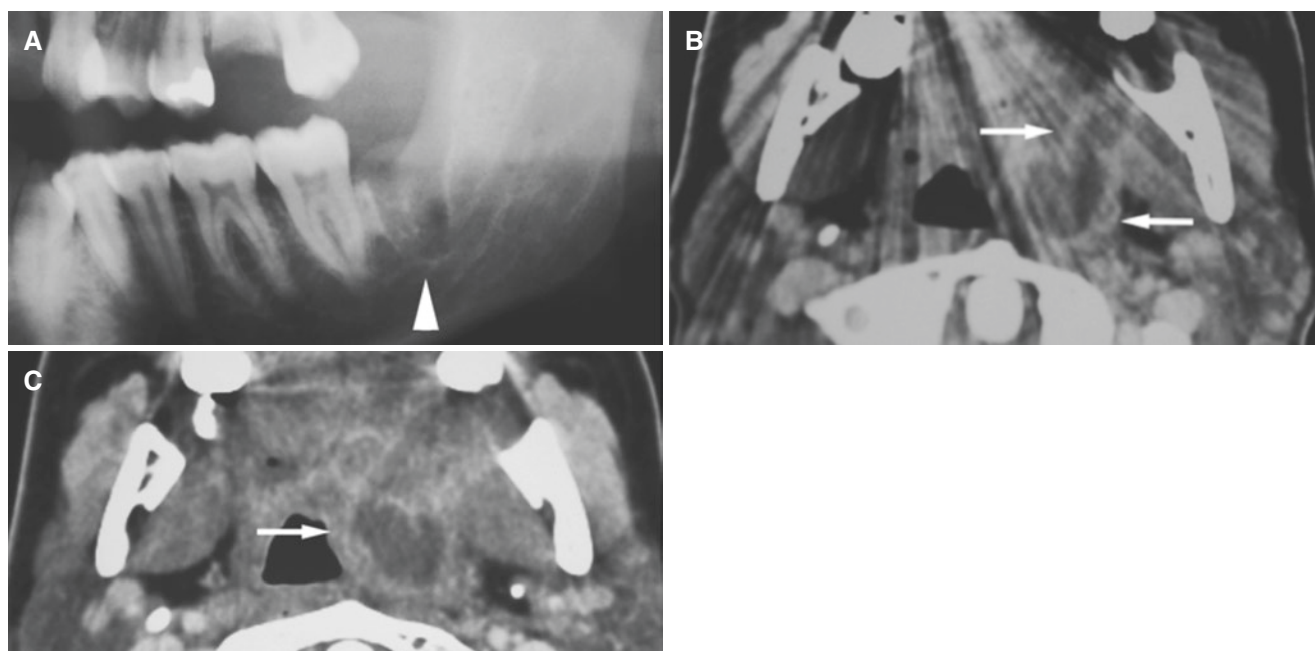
Abscess, parapharyngeal; 24-year-old female with pharyngeal swelling after extraction of infected third molar. (A) Panoramic view shows tooth socket (*arrowhead*) and infectious first molar in the maxilla. (B) Axial post-contrast CT image, soft-tissue window, shows
